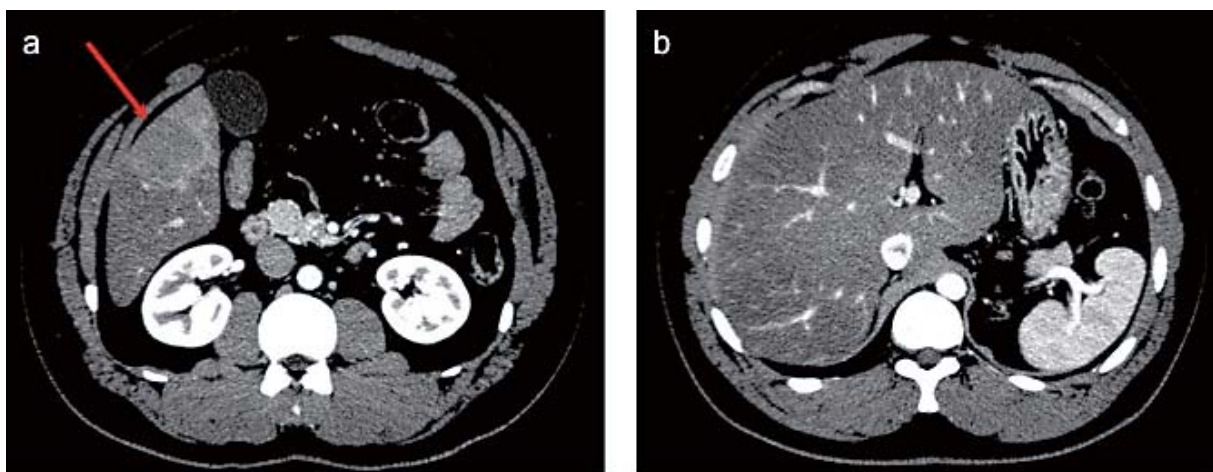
Contrast-enhanced computed tomography (CT) of the abdomen. (*1a*) Contrast-enhanced CT scan of the abdomen at the time of admission of the patient in June 2012 shows a clearly demarcated mass lesion, about 68 × 16 mm in size, at the inferior margin of the right hepatic lobe (*red arrow*). (*1b*) Contrast-enhanced CT scan of the abdomen obtained at the time of admission of the patient in June 2012 shows no abnormalities in the left lobe.
